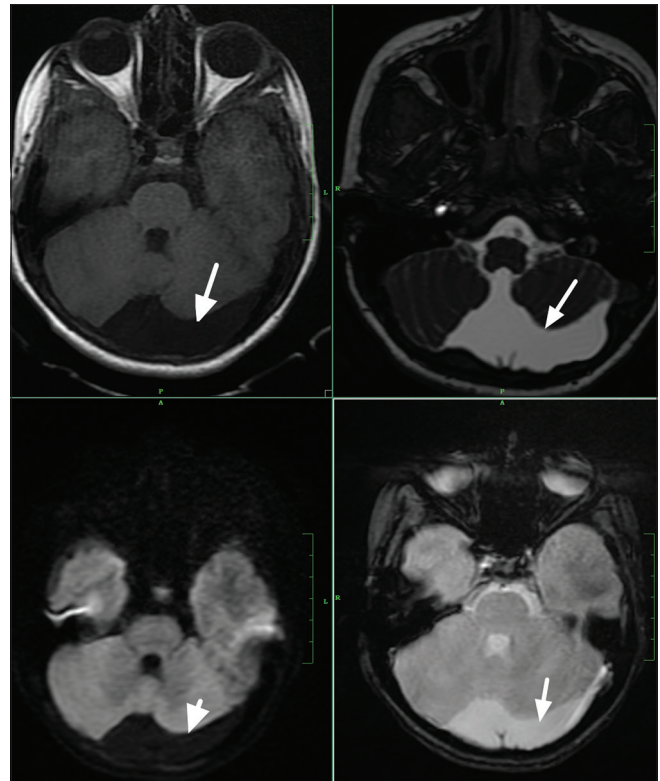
Axial sections of posterior fossa showing Retrocerebellar arachnoid cyst with classical CSF appearance on all images (Hyper in T2, Hypo in T1 and no DWI restriction) with mass effect over both cerebellar hemispheres
